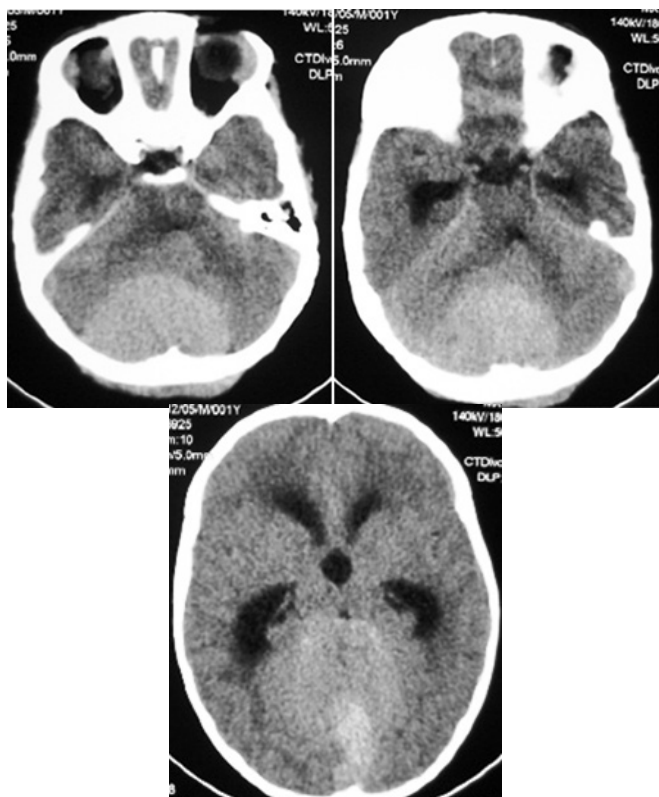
CT-scan without contrast showing an hyperdense infratentorial expansive mass and supratentorial hydrocephalus.
